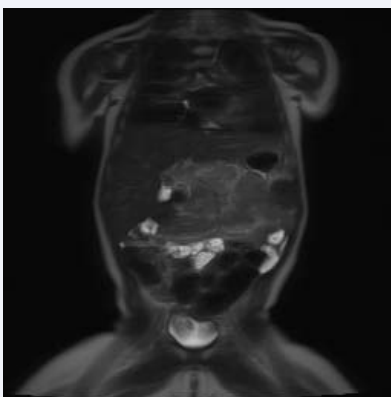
T1 non contrast MRI showing midline abdominal mass.
